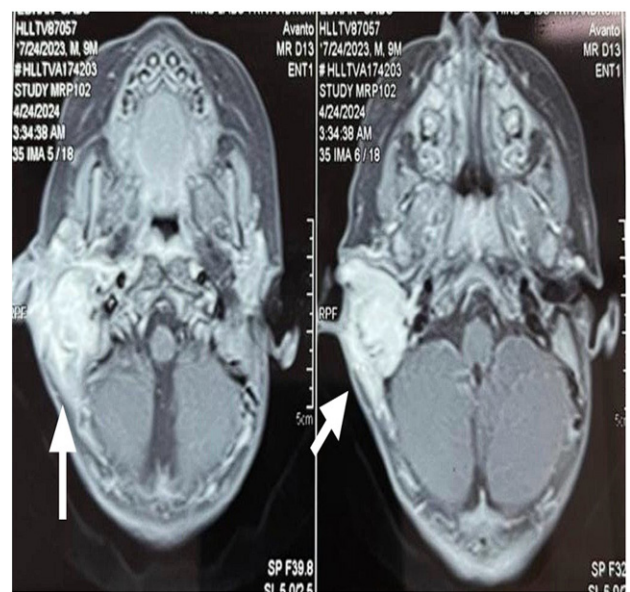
MRI Brain showing a large lytic lesion in the temporal bone with adjacent soft tissue enhancement
